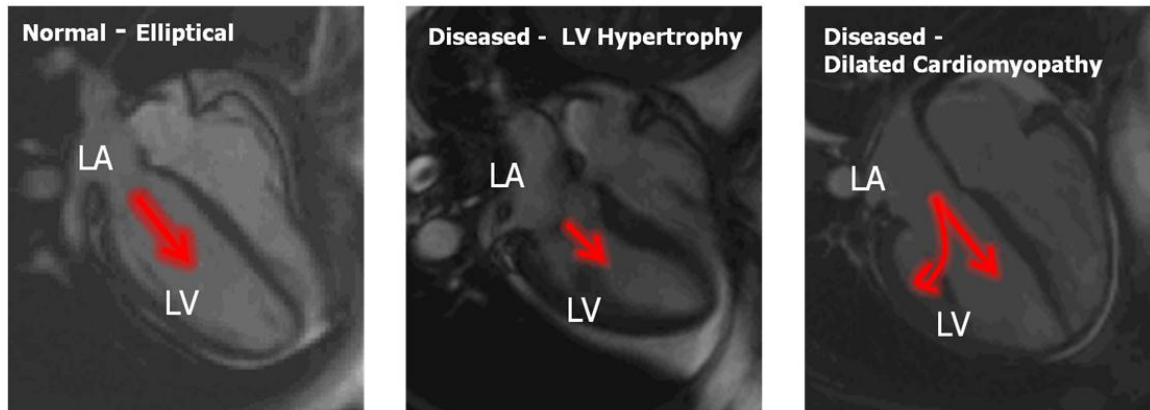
MRI Scans showing remodeled left ventricles in various states of disease. Left, normal LV. Center, hypertrophied LV showing thickened myocardial walls. Right, dilated LV showing thin walls and round, balloon shaped myocardium.
